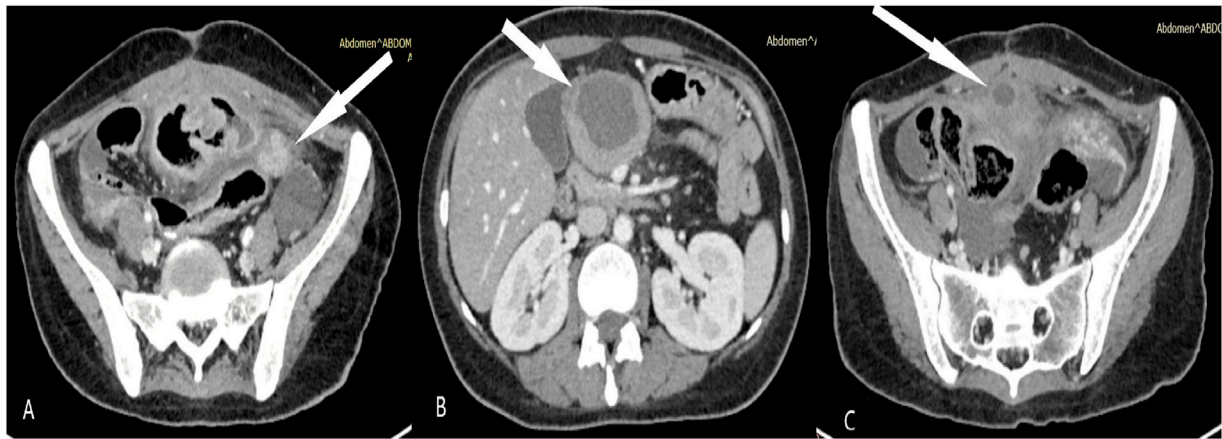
Abdominal-pelvic CT-scan. a: Tissular mass of the left pericolic gutter. b: Mesenteric lymph node with necrotic center. c: Uterine collection communicating with the anastomotic ileal loop.
